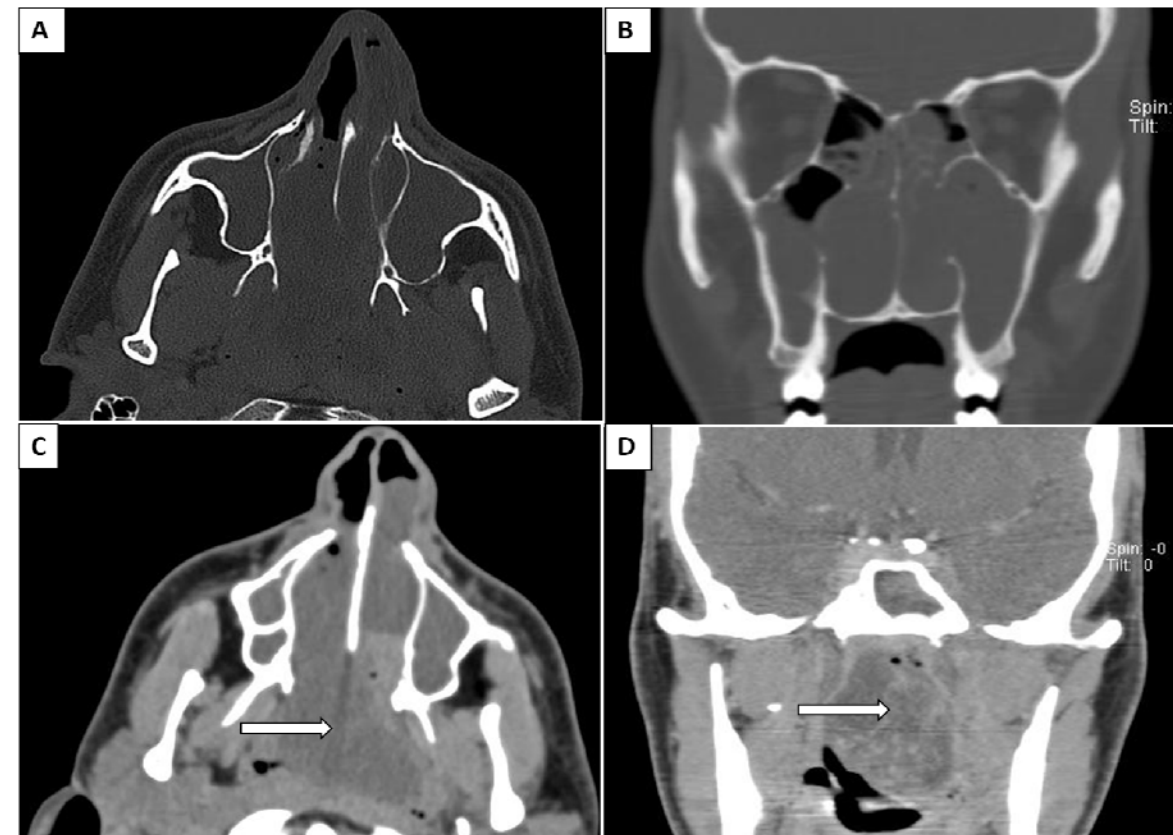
Axial (A) and coronal (B) computed tomography scanning of the paranasal sinuses (bone window) show complete opacification of the nasal cavity and nasopharynx, as well as bilateral maxillary and ethmoid sinus disease. There is no expansion of the sphenopalatine foramen or pterygopalatine fossa. Axial (C) and coronal (D) soft-tissue windows show a heterogeneous nasopharyngeal mass with possible necrotic regions.
